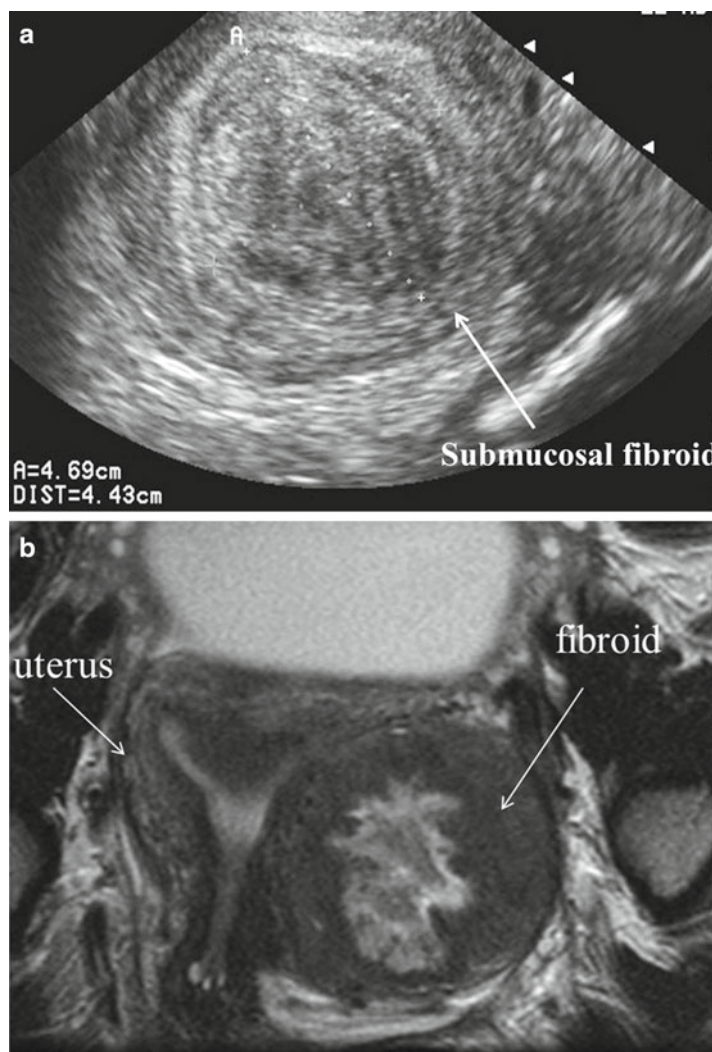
Radiographic imaging, uterine fibroid. Pelvic ultrasound (a) and MRI (b) images of uterine fibroid (arrows) (Used with permission of Susanna I. Lee MD PhD, Department of Radiology, Massachusetts General Hospital, Boston, MA)
